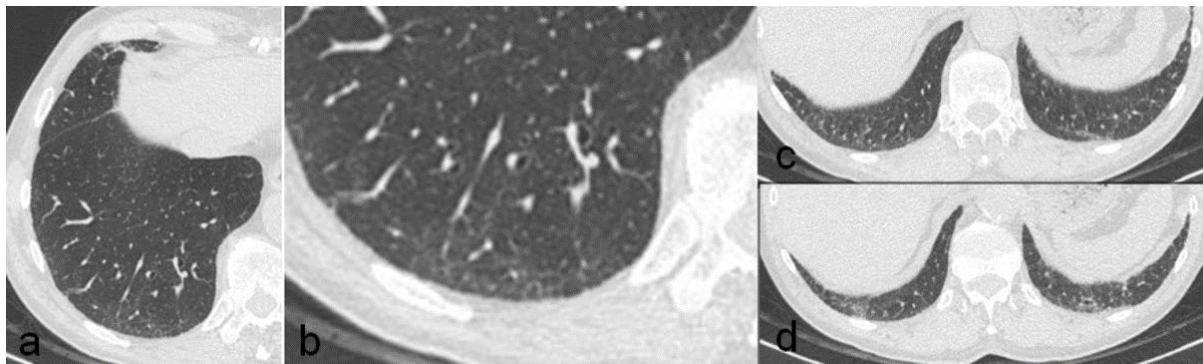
Chest CT (a,b,c,d) in a 79-year-old man with no respiratory functional tests changes show basal reticular thinckening and distal bronchial wall thickening; these radiological findings were stable for many years. RADIOLOGIA, OSPEDALE SS. ANNUNZIATA - Chieti/IT
